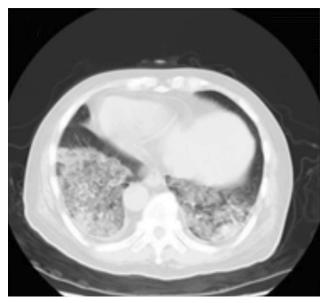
CT taken Day 2 indicating substantial bilateral ground-glass opacity and consolidation.
